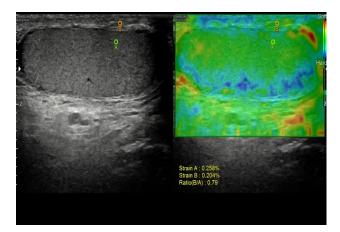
Trans-scrotal sonographic evaluation showing shear wave elastography of testicular parenchyma compared to scrotal subcutaneous fat.
